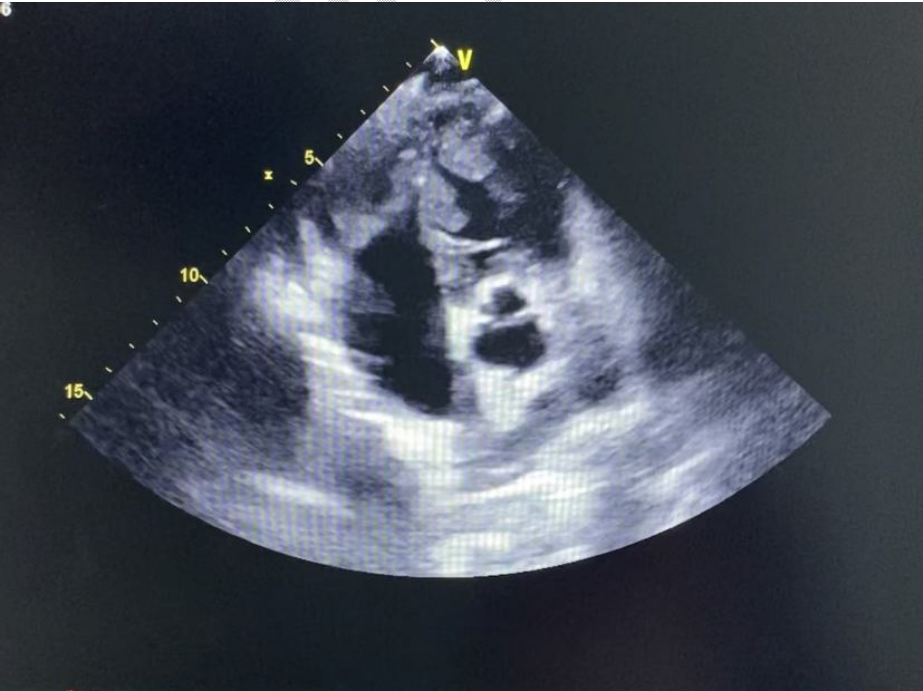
Short axis parasternal view echocardiography showing the large mass of the RV filling the pulmonary infundibulum
